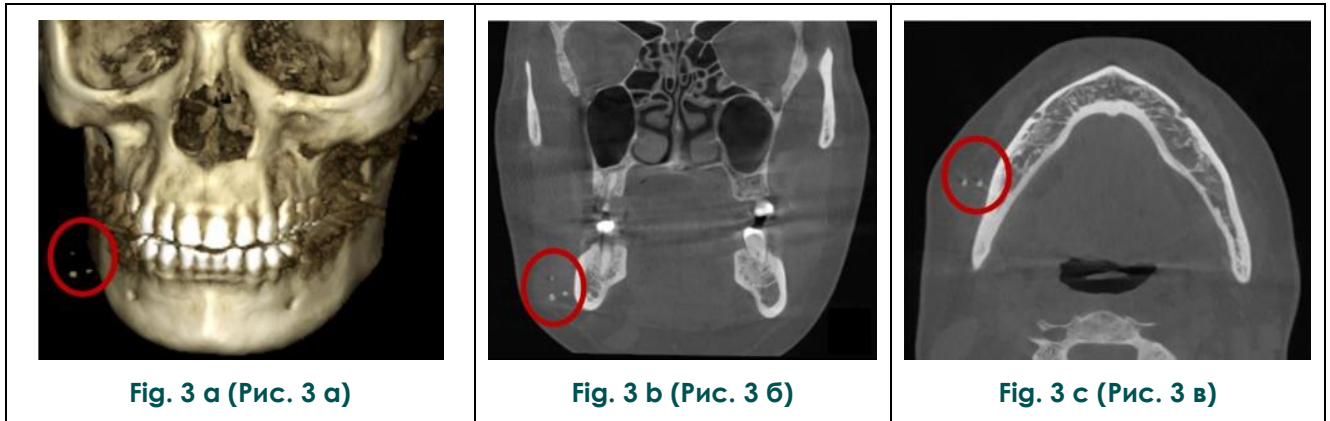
Cone-beam computed tomography.
